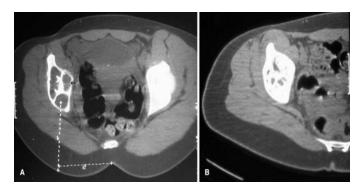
A Preoperative CT scan showing an aneurysmal bone cyst of the ilium with fluid-on-fluid levels. B 11 months after the second Polydochonol (Osteo Sclerosing agent) injection showing endosteal new bone formation with nonprogressive residual lytic areas.
